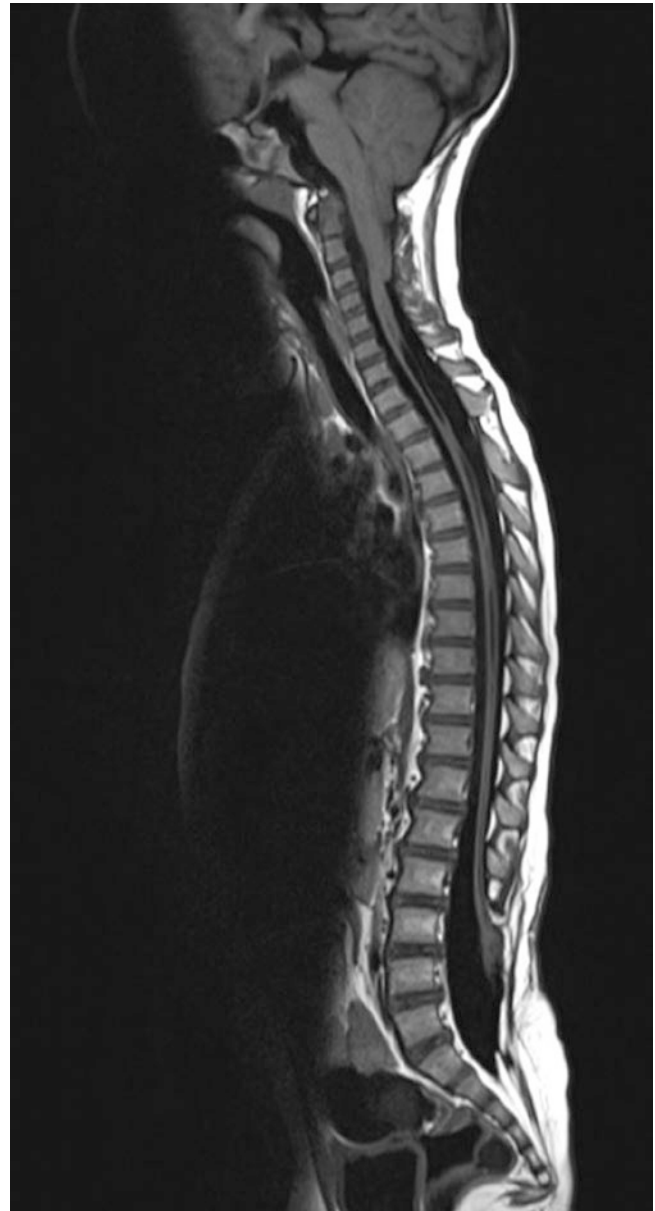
Sagittal T1-weighted MR image of the spine and posterior cranial fossa in a child with previous repair of lumbosacral myelomeningocele. Features of Chiari II malformation are present at the cranio-cervical junction. Linear areas of T1-hypointense signal (similar to CSF) within the spinal cord are consistent with syrinx
